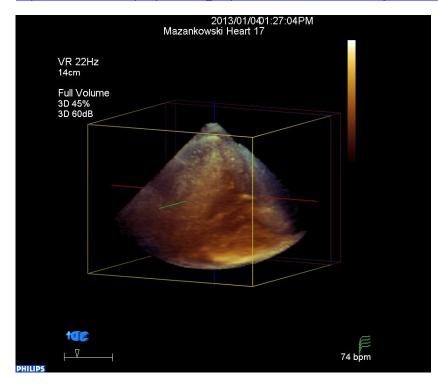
Image depicting the dispersion of ultrasound beams in a two-dimensional (a) and three-dimensional (b) transducer. Images sourced from the Philips Ultrasound website:
